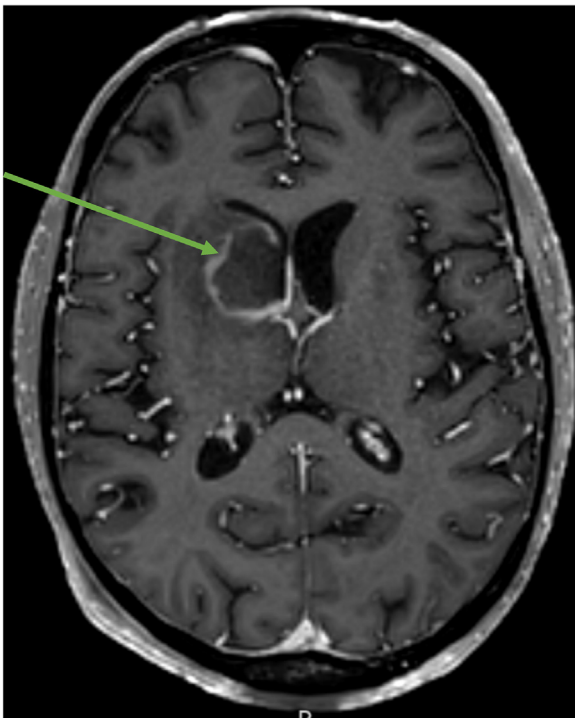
Brain magnetic resonance imaging study with contrast demonstrates a single rim-enhancing lesion (green arrow) involving the right caudate and basal ganglia with mass effect indenting the right lateral ventricle. Lumbar puncture cytology demonstrated B-cell lymphoma.
